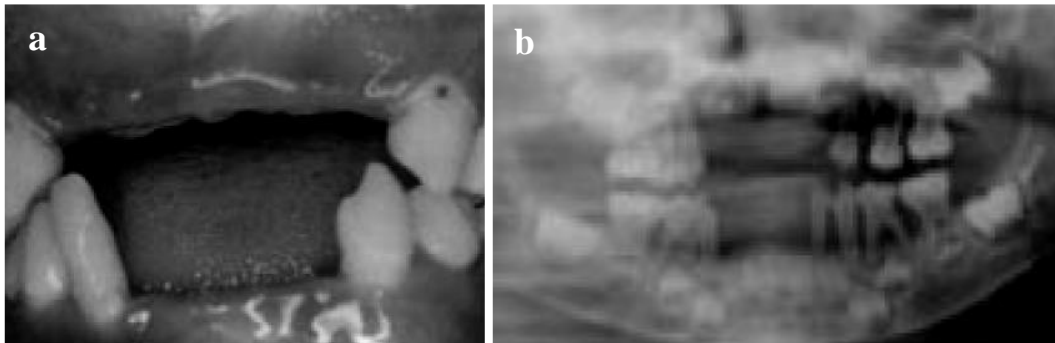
Patient with aggressive periodontitis type 1. (a) Clinical and (b) X-ray pictures demonstrate gingival recession and advanced alveolar bone loss around remaining primary dentation (Hart *et al.*, 2000c).
